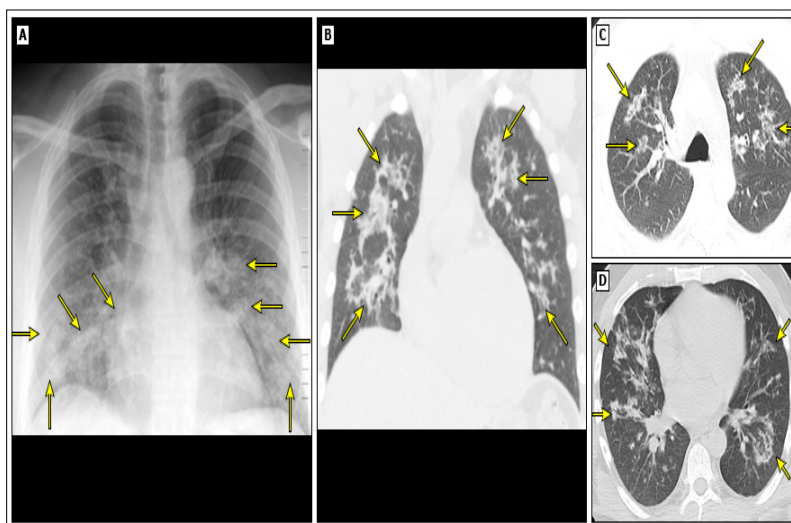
Acute eosinophilic pneumonia on radiography and CT.
